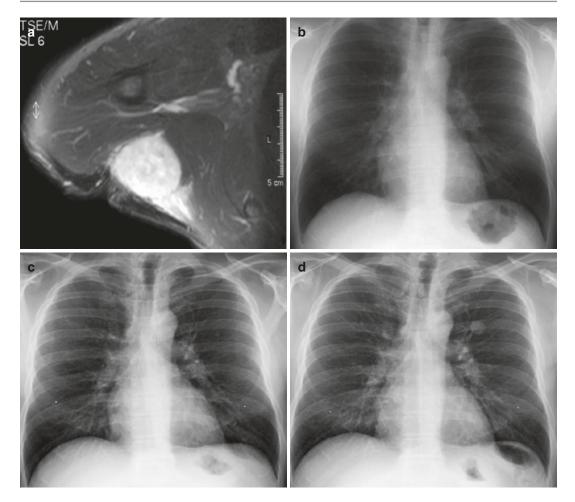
(a–d) Myxofibrosarcoma of the axilla in a 42-year-old man: (a) fat-suppressed axial T2-weighted MR image of the axilla. Staging chest CT at time of diagnosis demonstrated no lung metastases; (b) 3 weeks after
